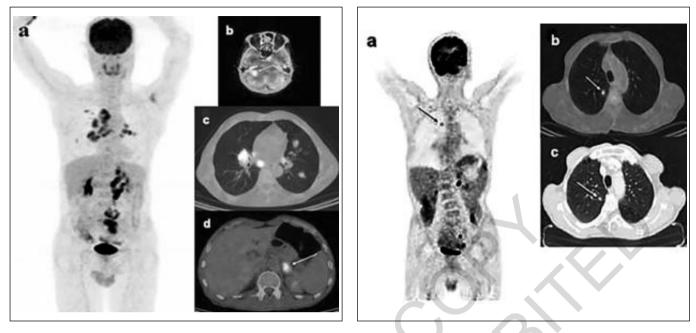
¹⁸F-FDG PET/CT of a 64-year-old man with rectosigmoid colon adenocarcinoma. A) Maximum intensity projection (MIP) whole body image and axial fusion images of B) brain, C) thorax, and D) abdomen showing high ¹⁸F-FDG uptake in metastatic lesions in brain, lung, mediastinal lymph nodes and left adrenal gland.
